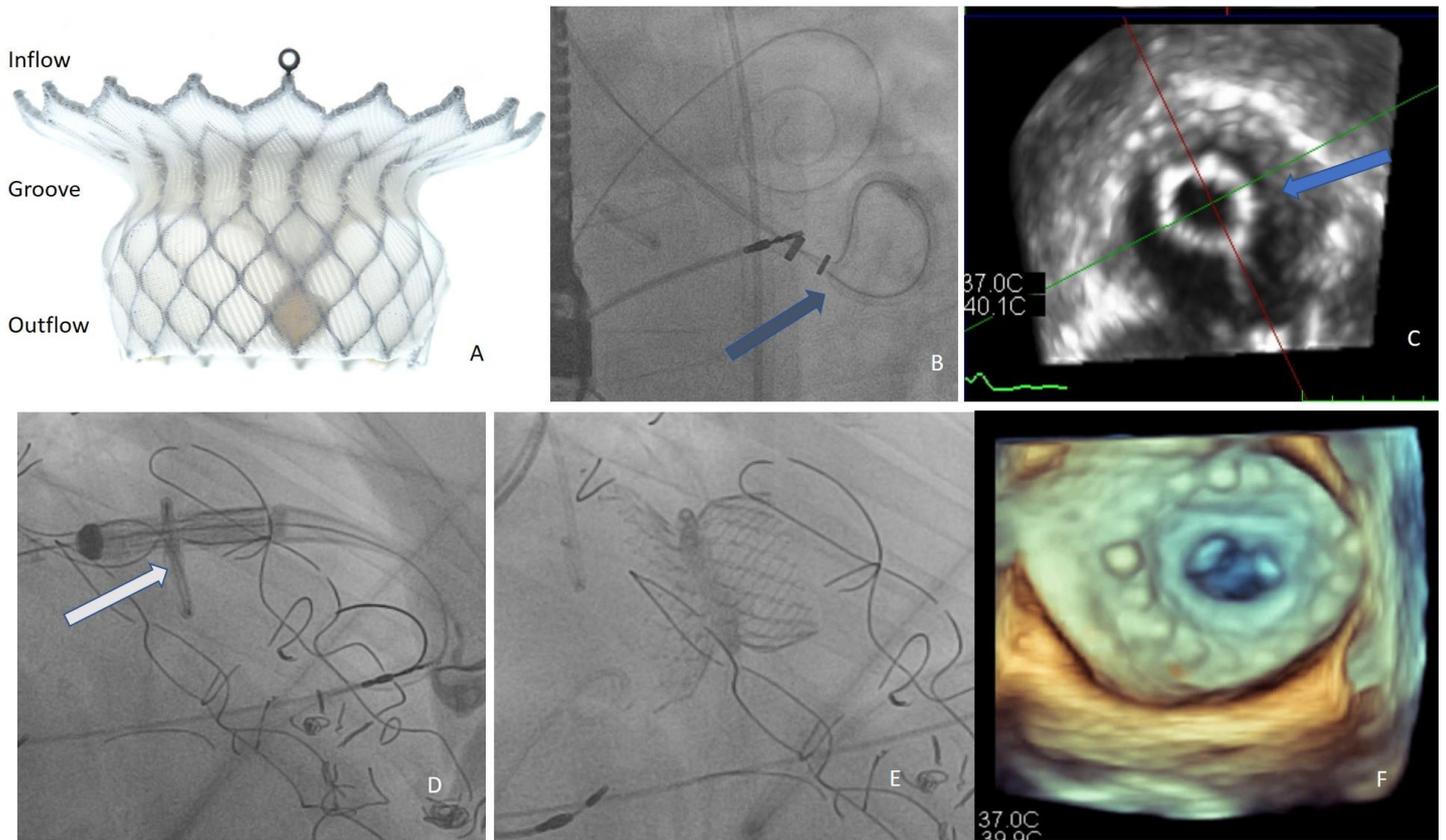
Fluoroscopy and transesophageal echocardiography depicting the steps of High Life valve implantation.
